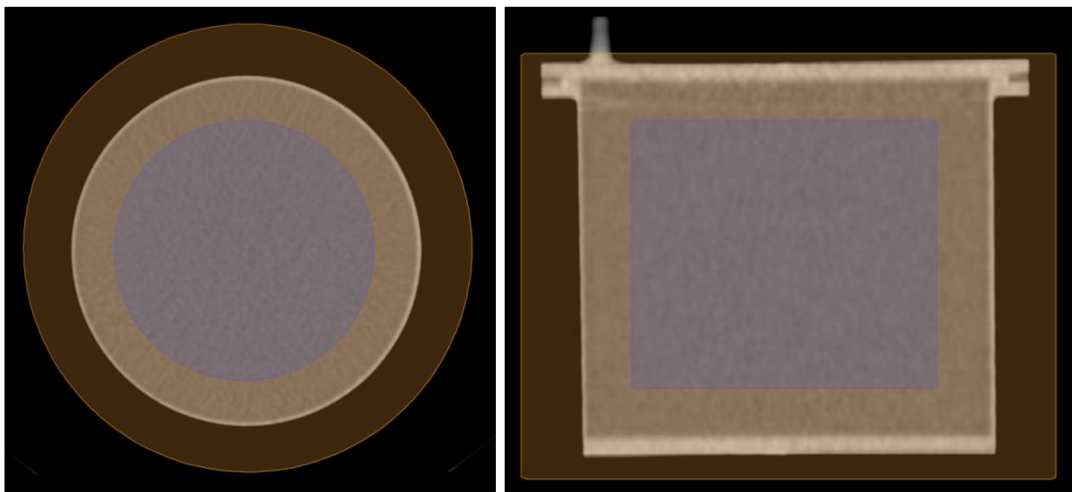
VOIs used for sensitivity analysis on CT image transverse (left) and coronal (right) central slices. The VOI using the MRTDosimetry Method is shown in orange and the small VOI using the EANM mIBG dosimetry method is shown in blue.
